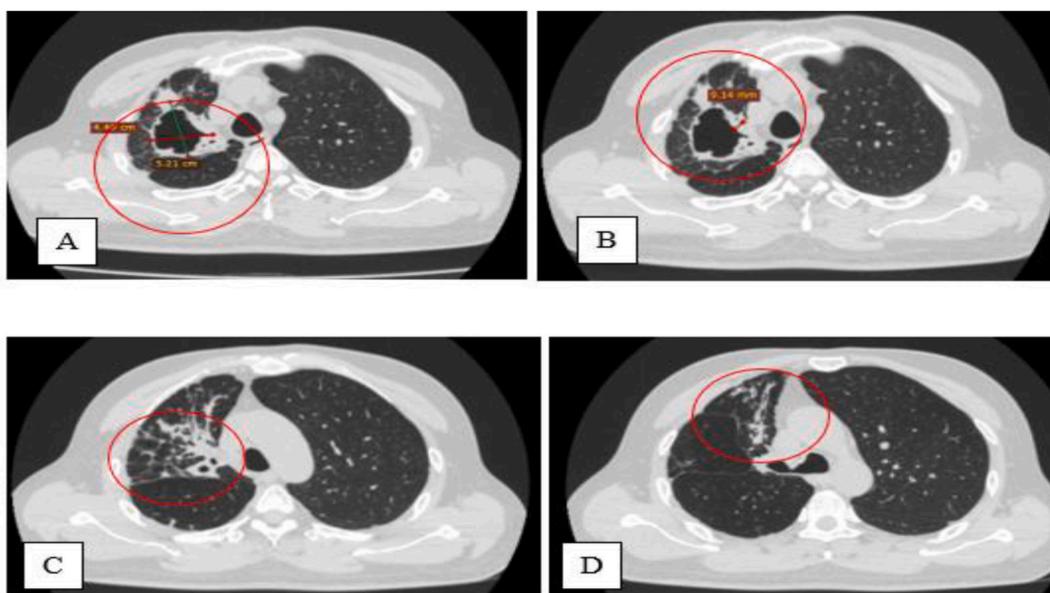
Thoracic HRCT image. A) Cavity diameter measurement, B) Cavity wall thickness measurement, C) and D) Fibrosis distribution in right lung segment.
